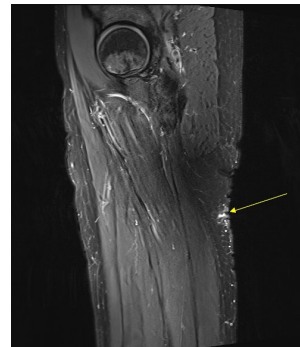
Preoperative MRI findings. Contrast-enhanced MRI reveals ill-defined enhancement in the subcutaneous and skin layers of the right proximal thigh. Although suspicious for postoperative changes, the focal T2 high signal intensity indicates potential remnant tumor.
